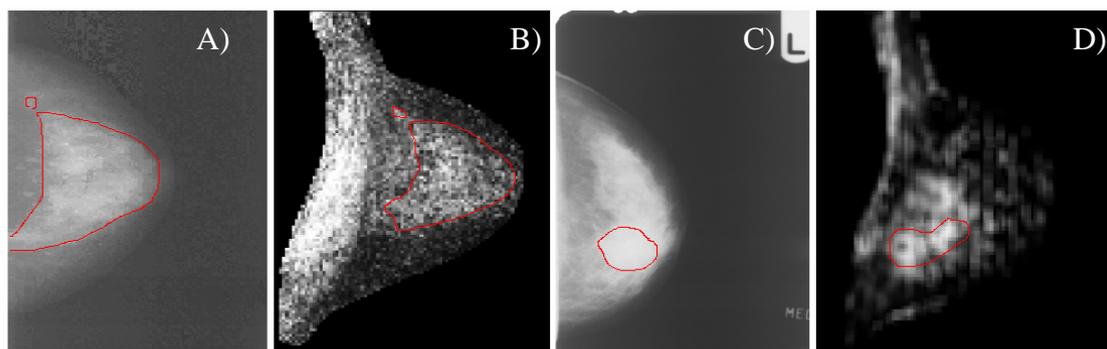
Two examples comparing the CC mammogram to corresponding contrast-enhanced MRI projections. The first example A), B) shows consistent shape characteristics of moderately-enhancing parenchymal tissue, due to ductal ectasia. The second pair C), D) compares the contrast of a large tumour in the X-ray image with the corresponding functional projection.
